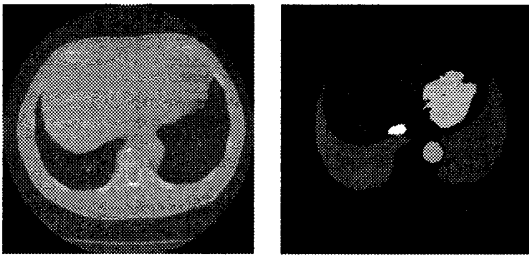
Left: a slice picked from one of the volumetric abdomen CT images. Right: its corresponding slice of the labeled image. Regions of liver, lung, and etc. are indicated by different labels
